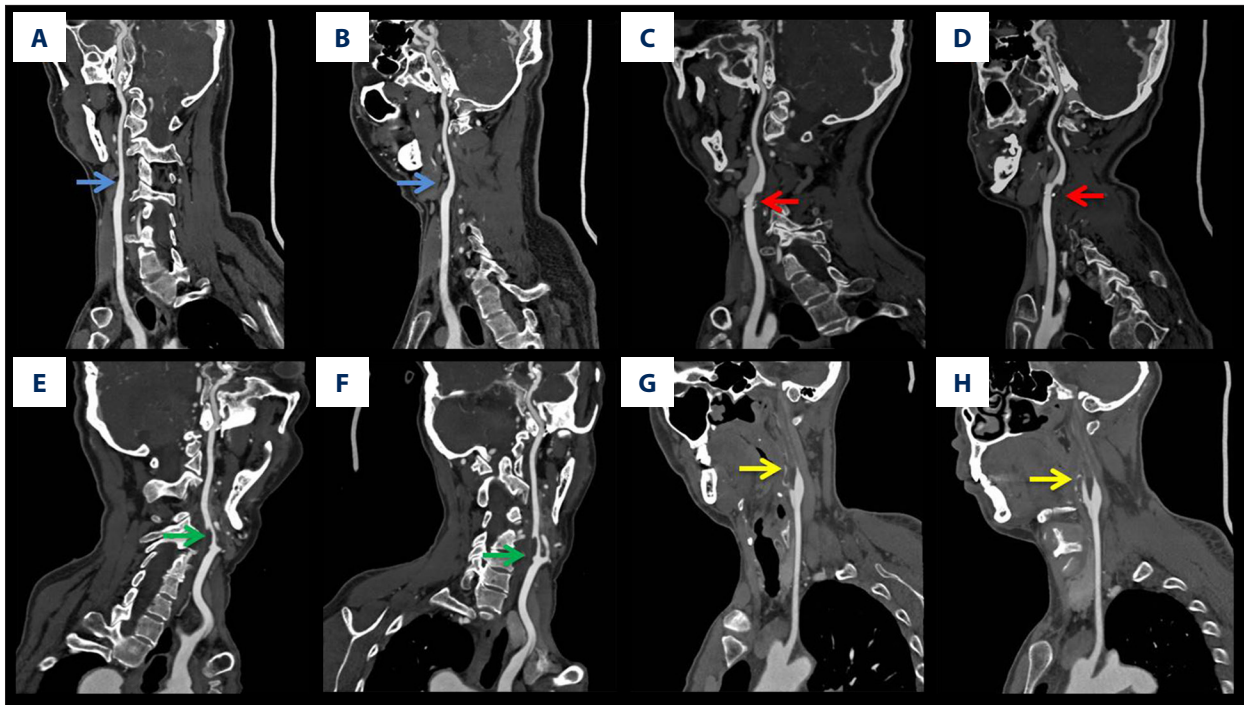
Computed tomography angiography evaluation of cervical vessels. (A, B) Mild stenosis was 0% to 29% (blue arrow). (C, D) Moderate stenosis was 30% to 69% (red arrow). (E, F) Severe stenosis was 70% to 99% (green arrow). (G, H) Complete occlusion was 100% (yellow arrow).
